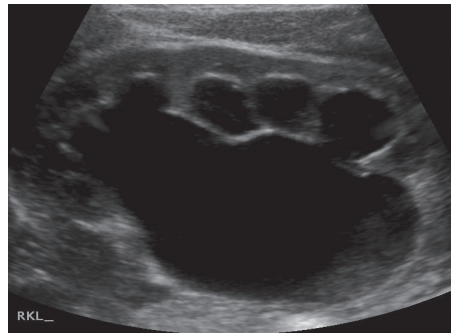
Renal ultrasound demonstrating severe hydronephrosis secondary to pelviureteric obstruction.
